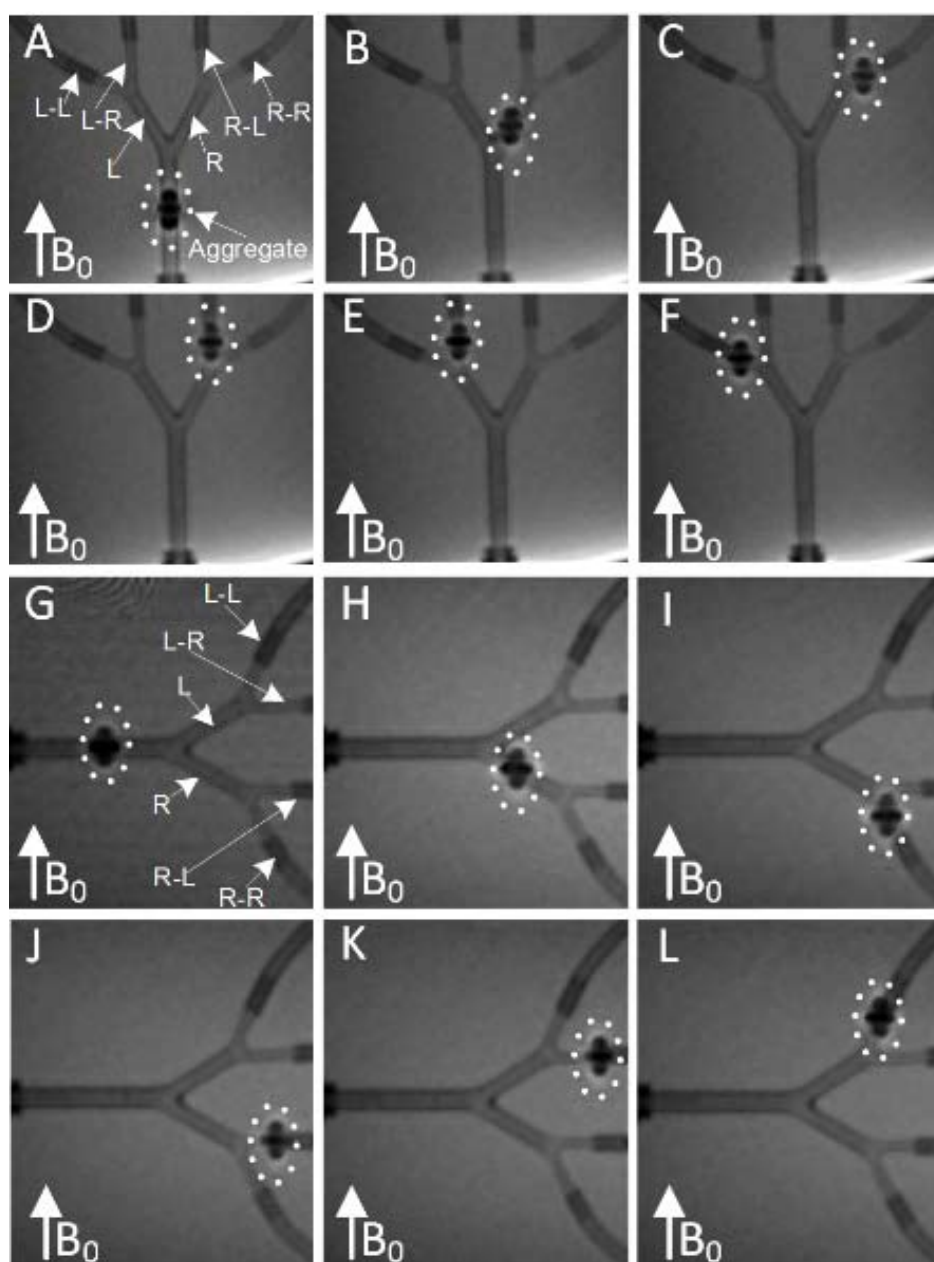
The particle aggregates were navigated into different second tube branches when the main tube is either parallel (A-F) or perpendicular (G-L) to  $B_0$ . The magnetic resonance imaging was taken from the coronal plane. Figure 6-8A-C and G-I show the particle aggregates reaching the main (A and G), first (B and H) and second (C and I) branches when carrying out R-R MRN. Figure 6-8B-E and I-L show that the particle aggregates had successfully reached four different second branches through MRN.
